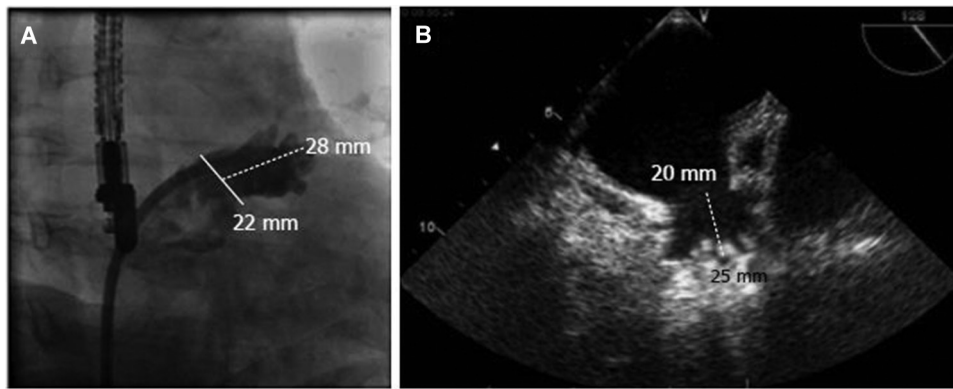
Measurement of the LAA during implantation of Watchman device. (A) After angiography (RAO: 25°, caudal: 20°), ostium size measurement (22 mm) and depth (28 mm); (B) measurement using echocardiography at around 135° of ostium size (20 mm) and depth (25 mm). Adapted from Möbius-Winkler et al.⁶⁾ LAA: left atrial appendage; RAO: right anterior oblique
